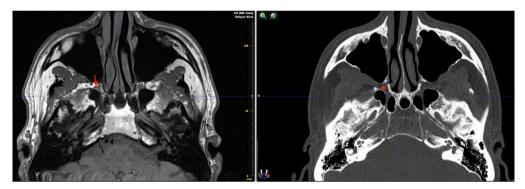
axial MRI (left, T1 sequence) and axial CT-scan at the same plan were fused using Brainlab iPlan 3.0 (Brainlab AG, Feldkirchen, Germany). The red arrow (left image) marks the right SPG. The red star (left image) indicates the position of the SPG on the fused axial CT-scan.
